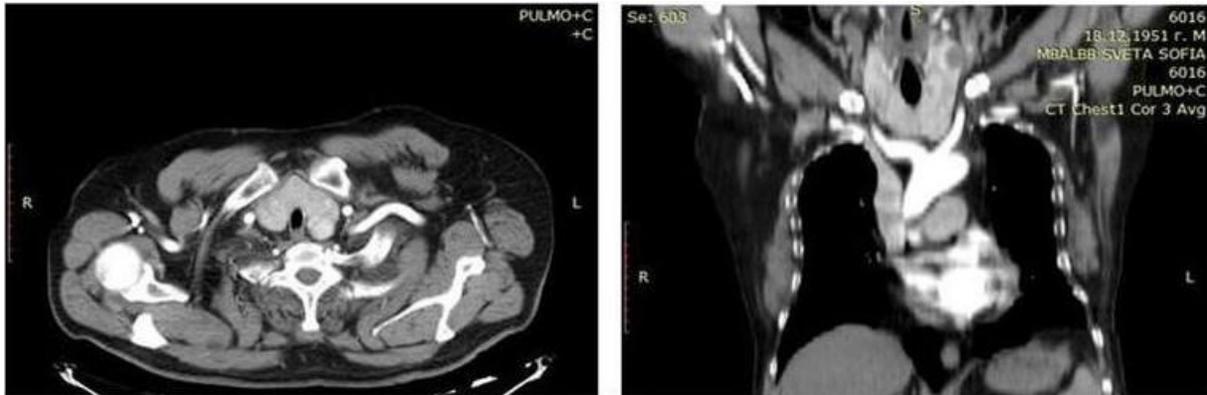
CT scan demonstrating a retrosternal goiter.
